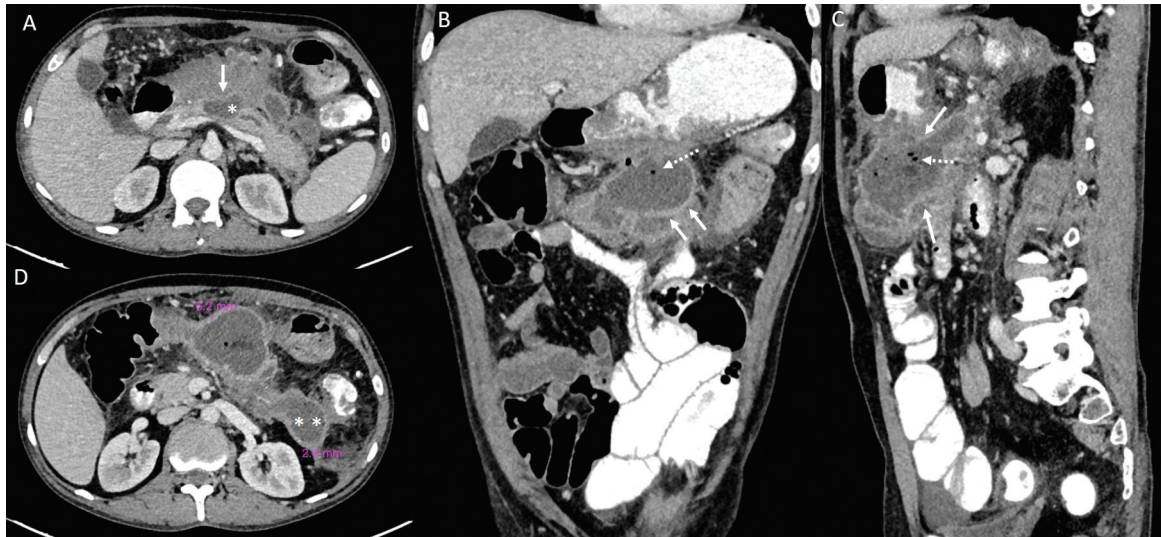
Follow-up contrast-enhanced computed tomography (CECT) (same patient as Fig. 1) in the fourth week of illness shows completely encapsulated lesser sac (white arrows in A–C) and left pararenal ( in D) collections with thicker walls in comparison to the baseline CT. Dashed white arrows in C and D denote presence of gas.
